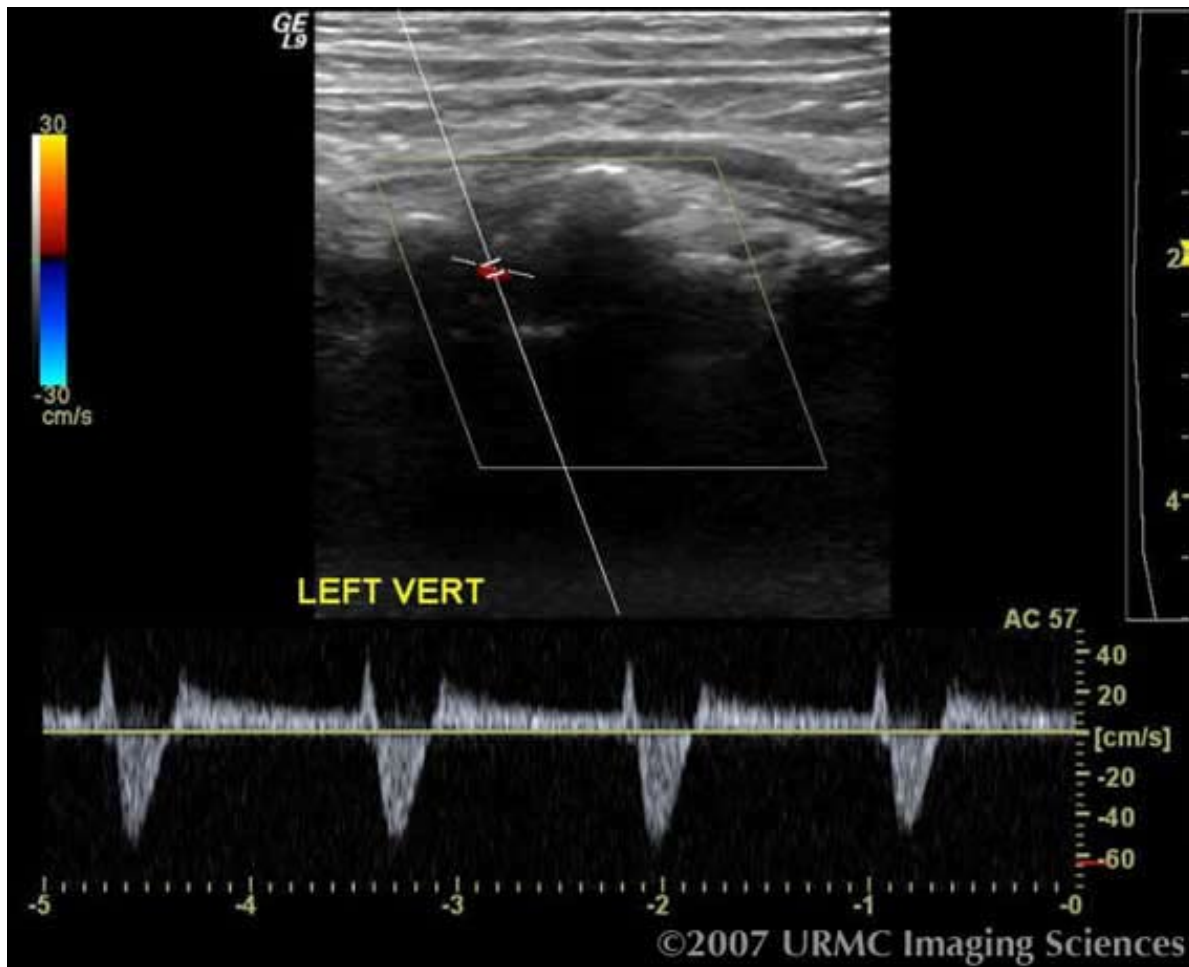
Color duplex ultrasound with signal from the left vertebral artery shows a biphasic signal with retrograde systolic flow.
